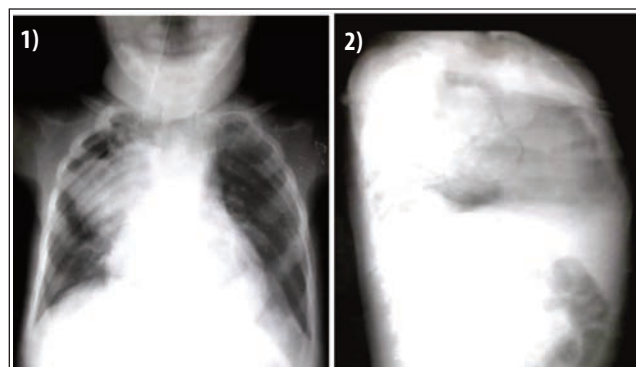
Images 1 and 2: Plain chest X-ray showing a mass in the right upper and middle zone with crowding of adjacent ribs, Plain X-ray chest on lateral view shows a posterior mediastinum mass which is displacing the oesophagus and the trachea forward.
